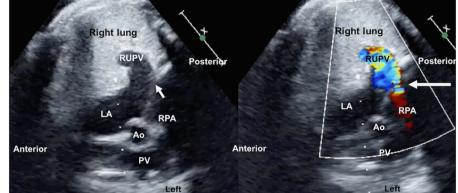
Fetal echocardiography. B mode (*a*) and color Doppler imaging (*b*) of the fistula from the right pulmonary artery (RPA) to the left atrium (LA) with dilated right pulmonary veins (RUPV) shown on fetal echocardiography done at 28 weeks' gestation. Arrow points to the communication between RPA to LA. Ao=aortic root; PV=pulmonary valve.
